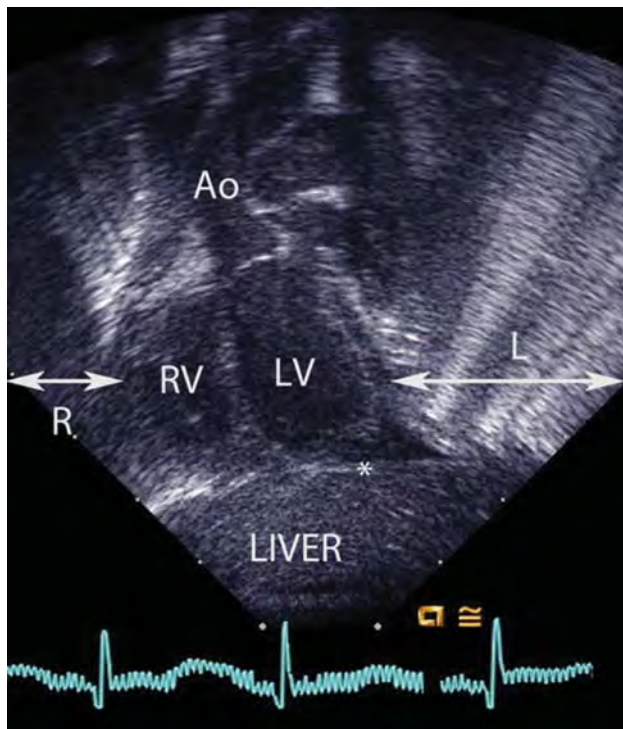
Subxiphoid coronal echocardiographic image showing the cardiac mass shifted rightward because the left arrow (L) is larger than the right (R). The cardiac apex in this example remains leftward (asterisk). Ao, ascending aorta; LV, left ventricle; RV, right ventricle.
